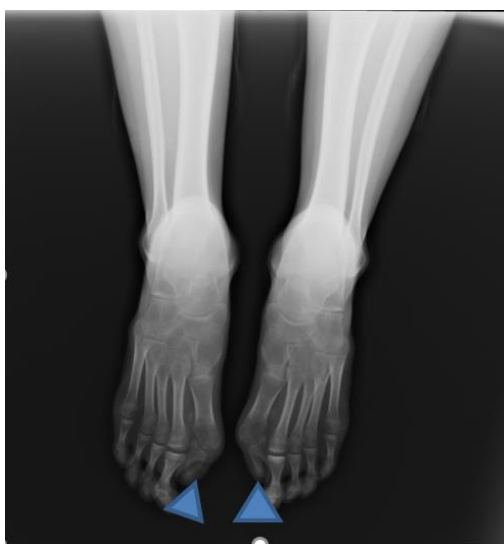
Bilateral foot radiographs
